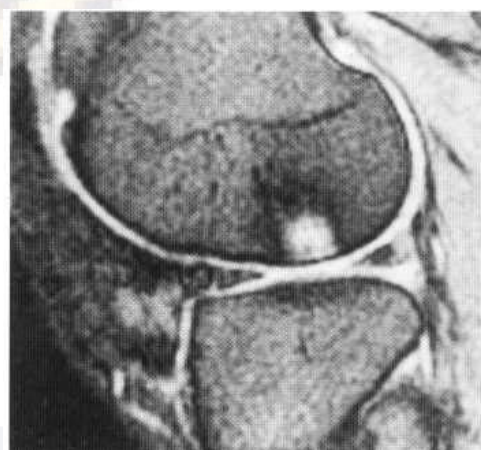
Bone 'bruising' of the femoral condyle, following knee dislocation. MRI gradient-echo image, showing the typical appearances of a focal area of increased signal.
